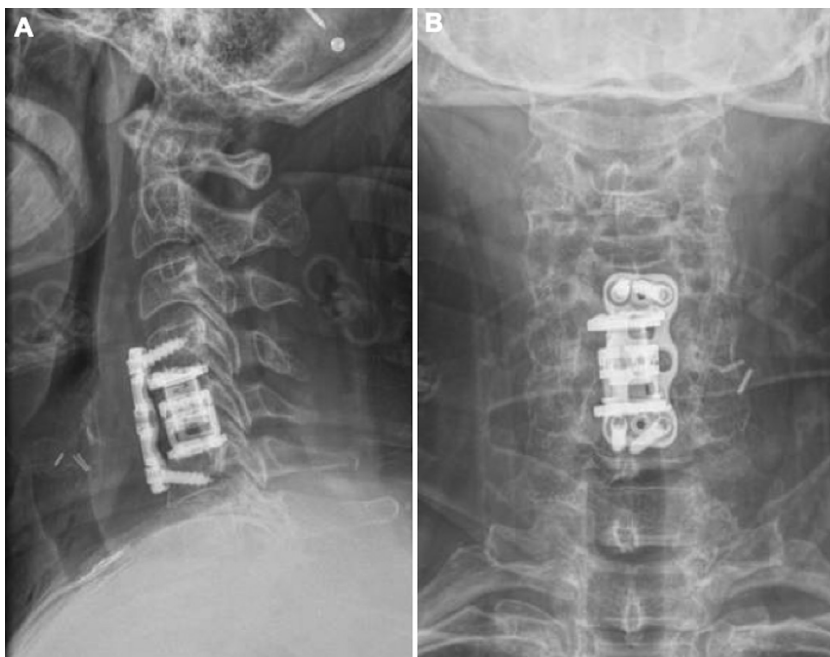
Panel A shows the lateral and Panel B shows the AP postoperative radiographs showing good position of the implants after a C5 corpectomy, C4–5 and C5–6 discectomy and fusion with cage placement.
